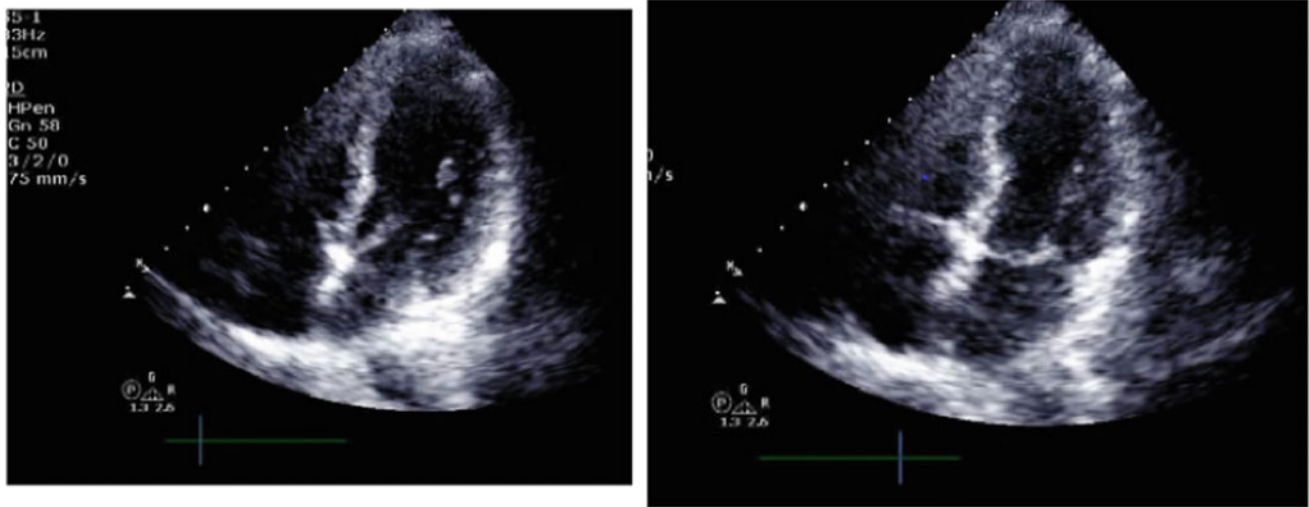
Left and right panels showing diastolic and systolic images from echocardiogram at presentation. There is antero-apical hypokinesia and a moderately reduced left ventricular ejection fraction
